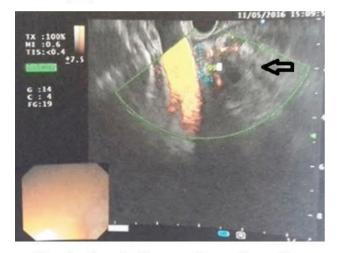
endoscopic ultrasonography revealing a welldemarcated hypo echoic mass at the head of the pancreas
